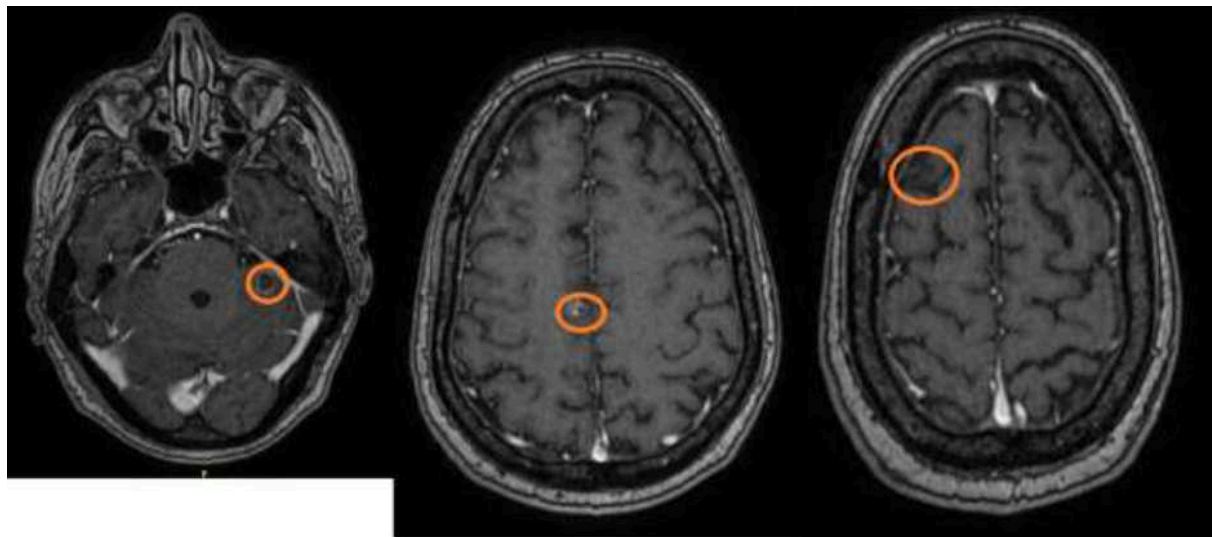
MRI brain 5 months after radiotherapy
